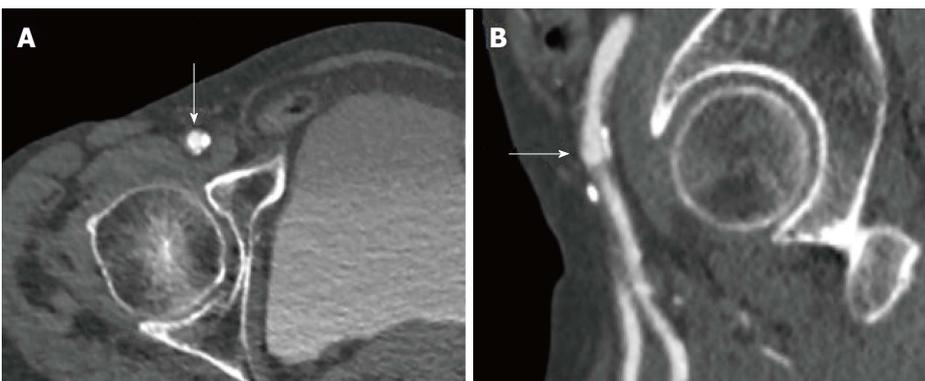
Multislice computed tomography showing calcified right common femoral artery in a patient undergoing transfemoral transcatheter aortic valve implantation. A: Right common femoral artery with an arrow pointing at the ideal puncture site above the calcification; B: Right common femoral artery with an arrow pointing at the ideal puncture site above the height of bifurcation of the common femoral artery in relationship to the femoral head.
